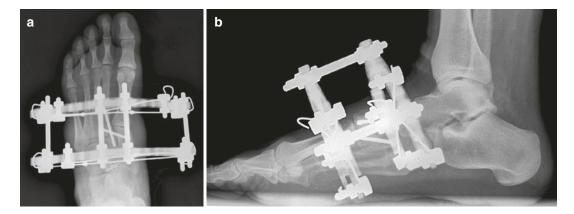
(a) AP and (b) Lateral X-Ray of left foot showing placement of an external fixator
